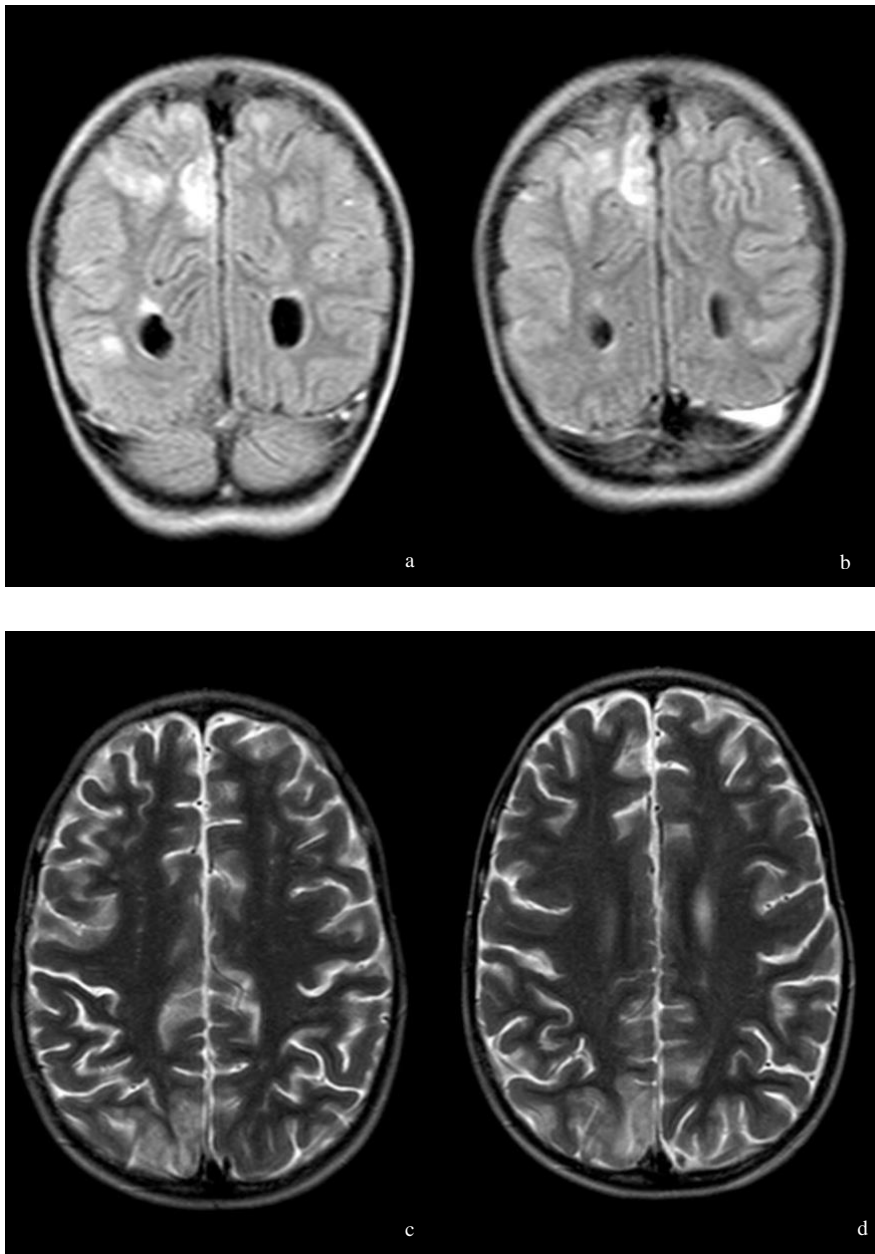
MRI at PRES onset showing FLAIR (a,b) and T2-weighted (c,d) subcortical hyperintensities in occipital regions with right predominance.
